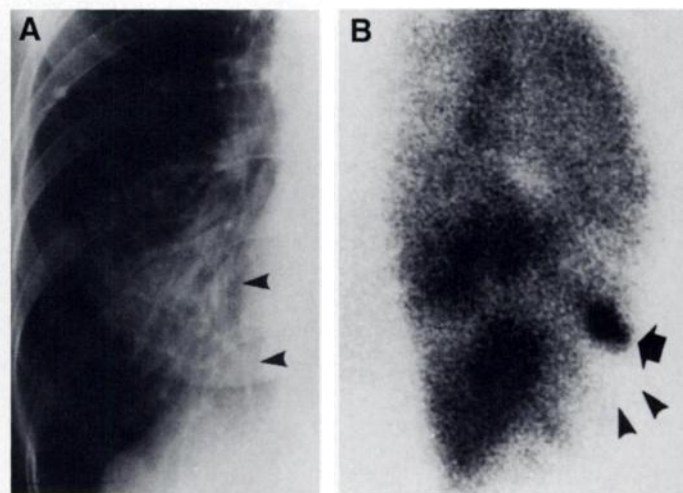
Decisive role of aerosol scanning in sublobar, bronchial obstruction in a 61-yr-old woman with chronic pneumonia in the medial segment of the right middle lobe. (A) Posteroanterior right lower chest radiograph shows an inconclusive density in the right paracardiac region (arrowheads). Obstruction is not shown. (B) Right lateral aerosol scan reveals intense tracer deposition in the proximal middle lobe bronchus (arrow) with accompanying deposition defect in the distal lung (arrowheads).
